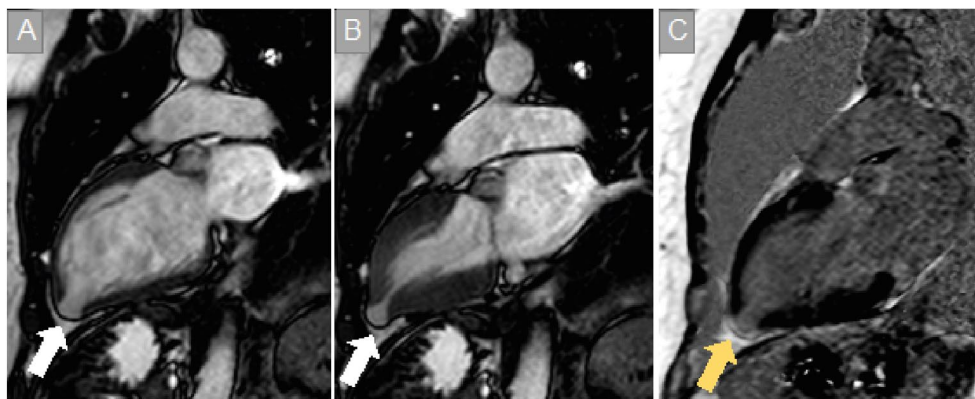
Narrow neck aneurysm at the apex of the left ventricle. Two-chamber tomographic sections obtained by cine-magnetic resonance imaging in ventricular diastole (A) and systole (B) showing a small apical aneurysm region. Myocardial scar evidenced by hypersignal intensity in the region of the aneurysm in a delayed gadolinium enhancement sequence (C).
